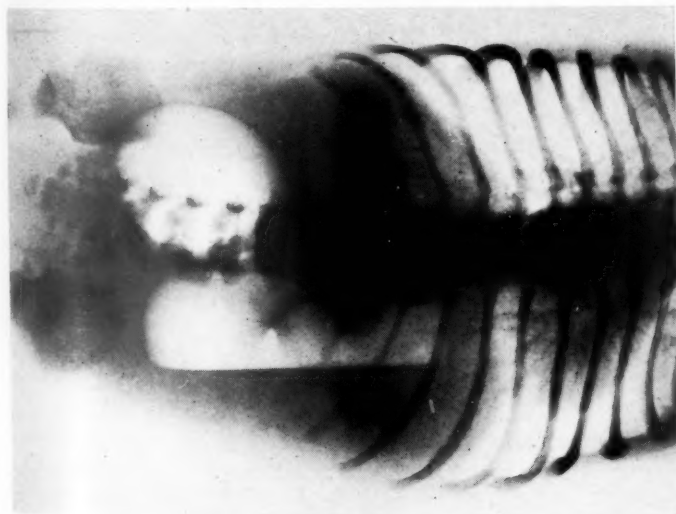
Case 3: radiograph of the abdomen (patient lying on the left side). The stomach and first part of the duodenum are outlined by air. There is no air in the rest of the small intestine.
